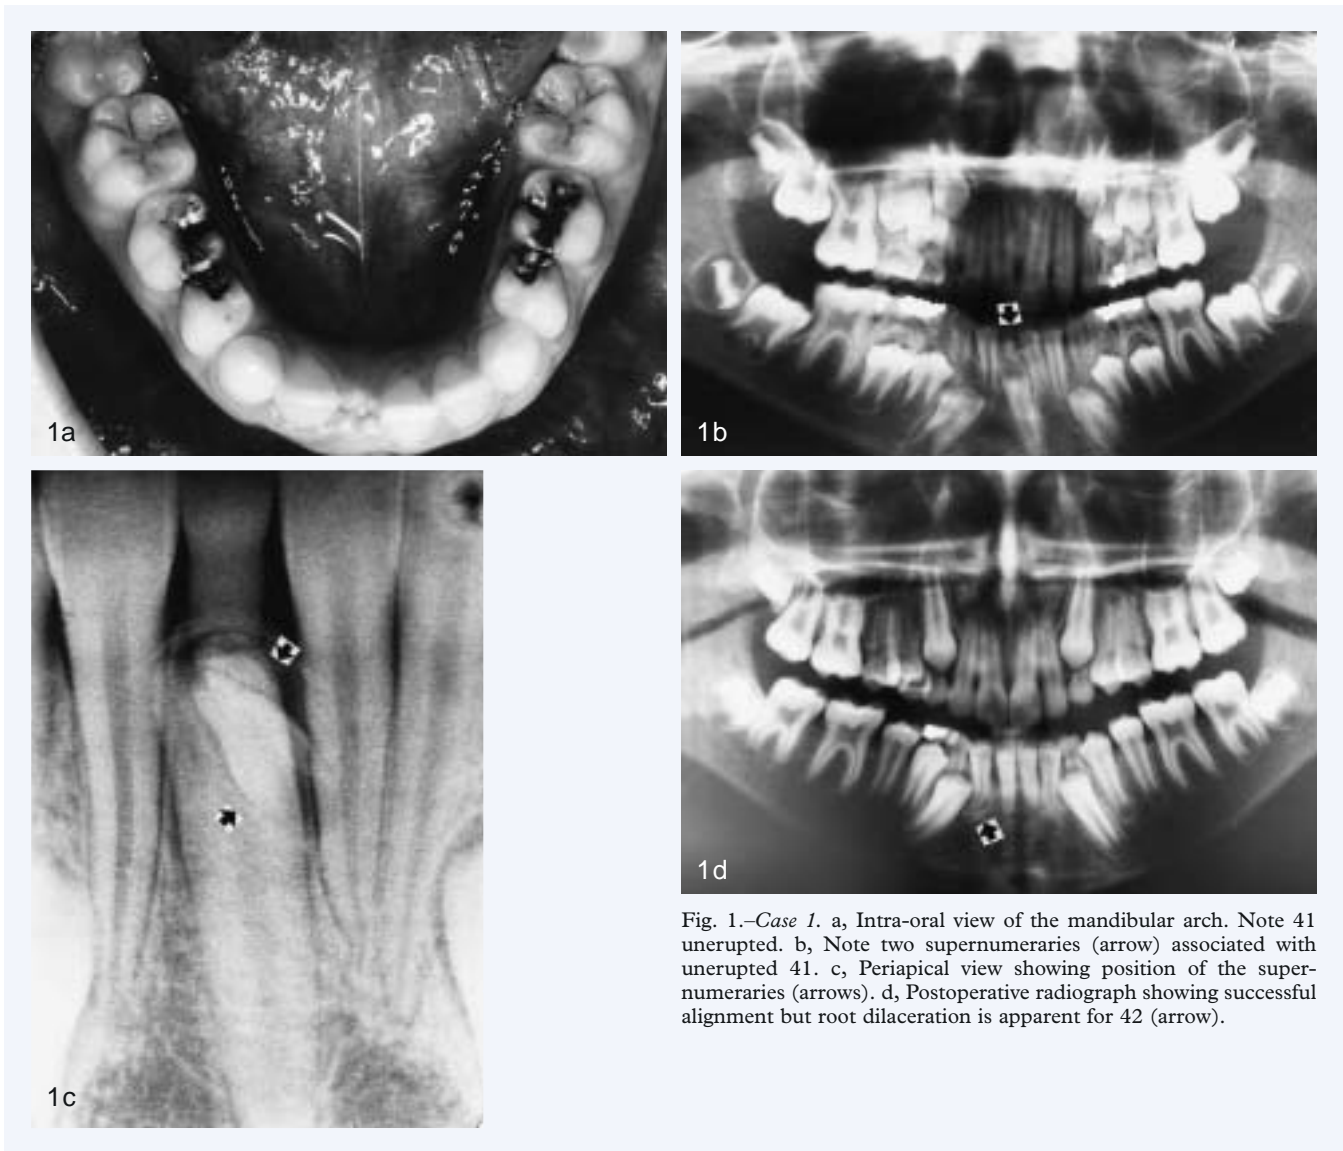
Case 1. a, Intra-oral view of the mandibular arch. Note 41 unerupted. b, Note two supernumeraries (arrow) associated with unerupted 41. c, Periapical view showing position of the supernumeraries (arrows). d, Postoperative radiograph showing successful alignment but root dilaceration is apparent for 42 (arrow).
